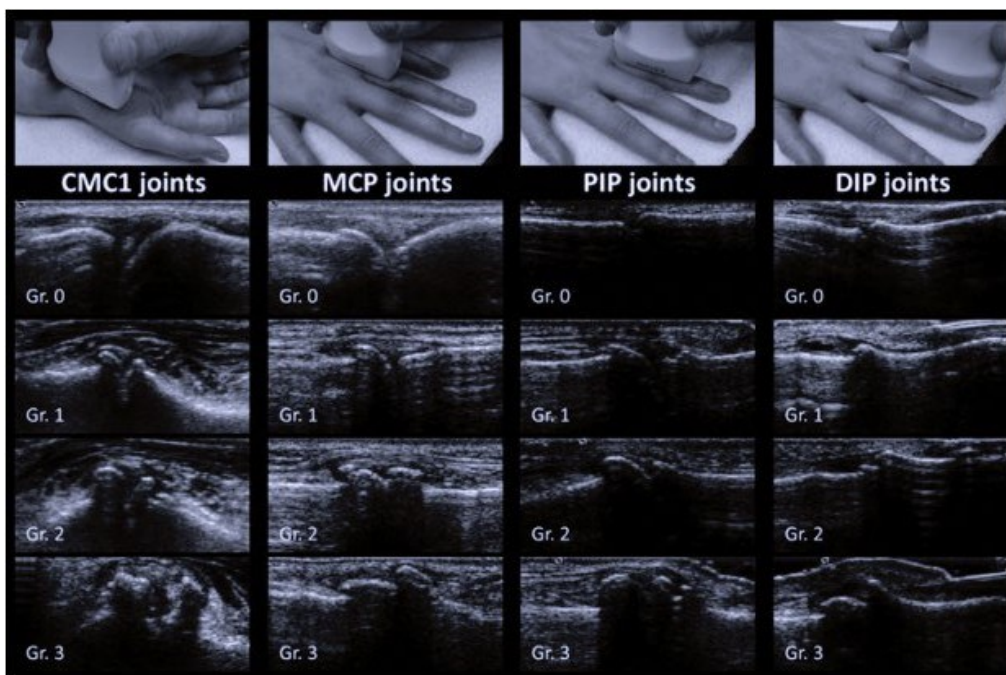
Ultrasound atlas of osteophytes. Osteophytes graded from 0 to 3 are depicted for the different joints of the hand (CMC, MCP, PIP, DIPS). The distal part of the joint is oriented on the right. (80) Used with the kind permission of BMJ Publishing Group Ltd.
